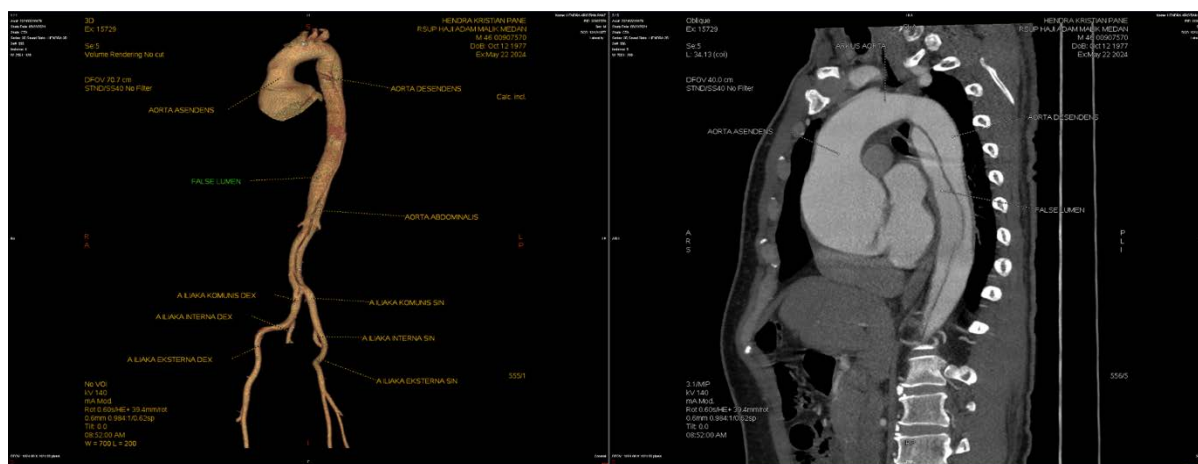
Computed Tomography shows multiple Aortic dissection at sinotubular junction and descending aorta
